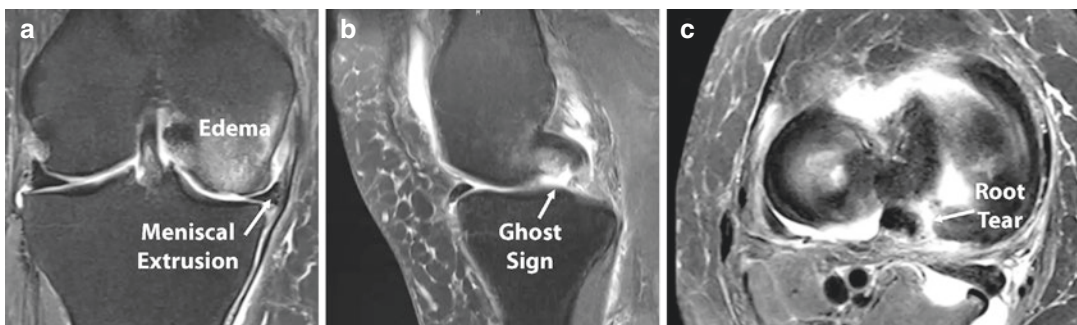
Magnetic resonance imaging of the right knee demonstrating (a) meniscal extrusion (>3 mm) and an edema of the medial femoral condyle on a coronal cut. (b)
